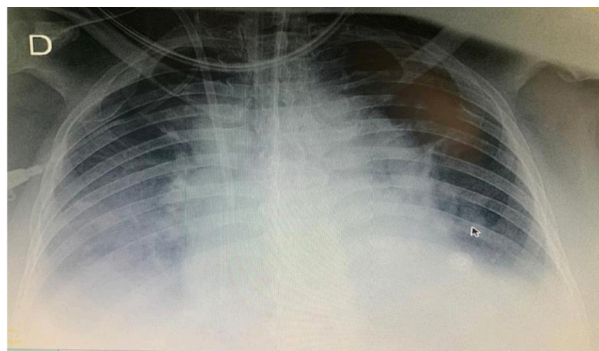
Chest X-ray after the second day of hospitalization.
